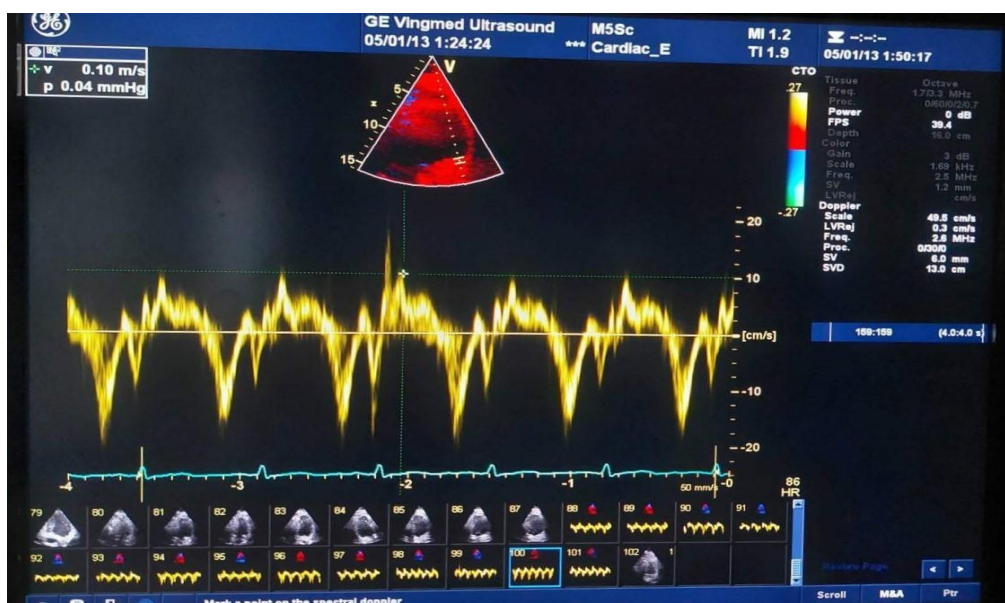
measurement of $S^{\wedge}$ of anterolateral wall using TDI and PW in apical 4 - chamber view
